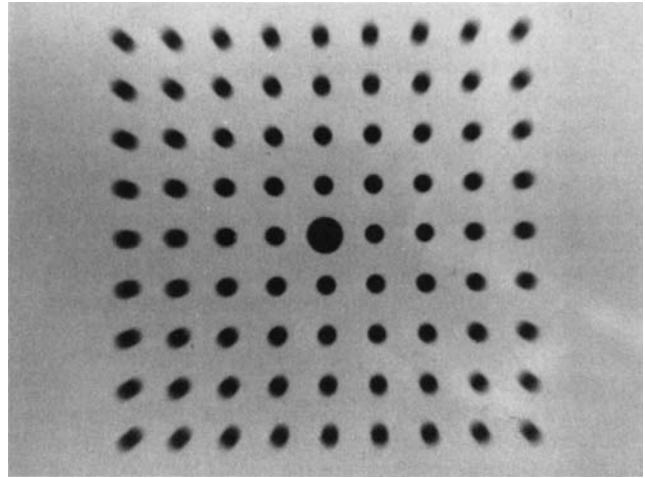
A radiograph of a device utilized to locate the central axis of the X-ray beam.
